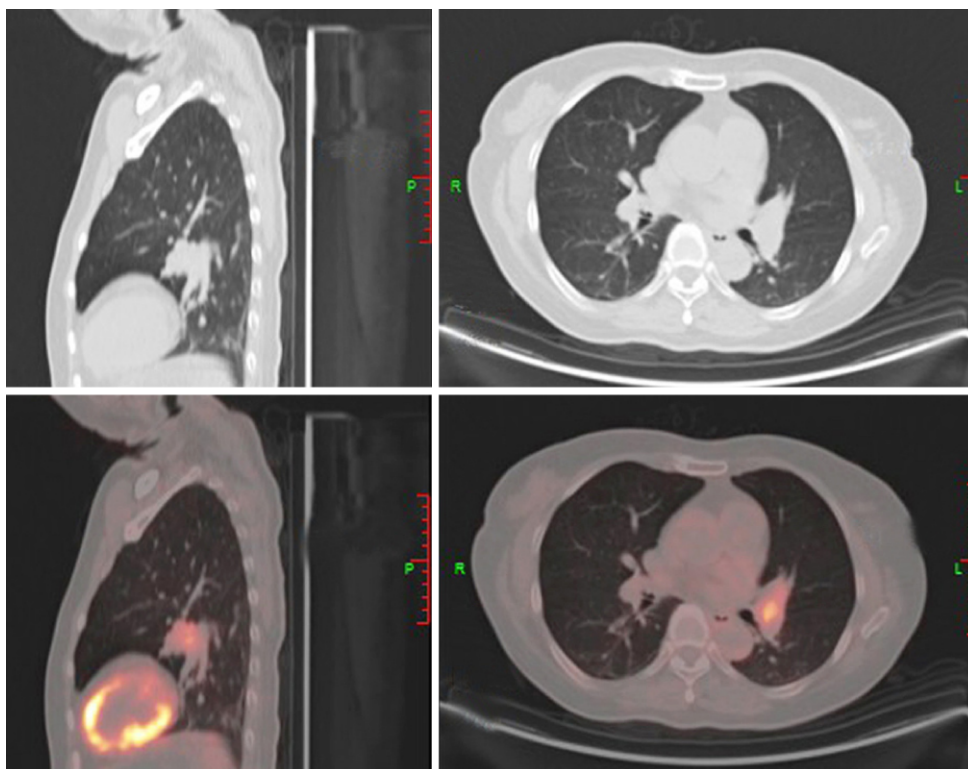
Positron emission tomography-computed tomography of Case 2. A hypermetabolic nodule is visible in the left lingular lobe (central lung cancer).
